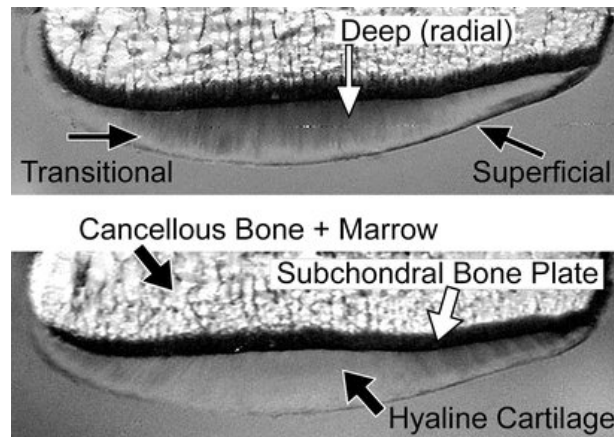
Structure of Articular Cartilage by MRI Imaging [22].
